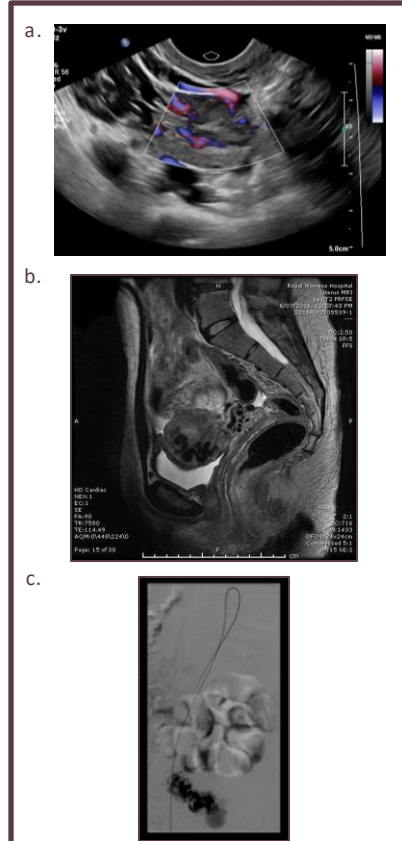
Appearances of the true AVM obtained on a) USS with colour doppler b) MRI c) CT angiogram
